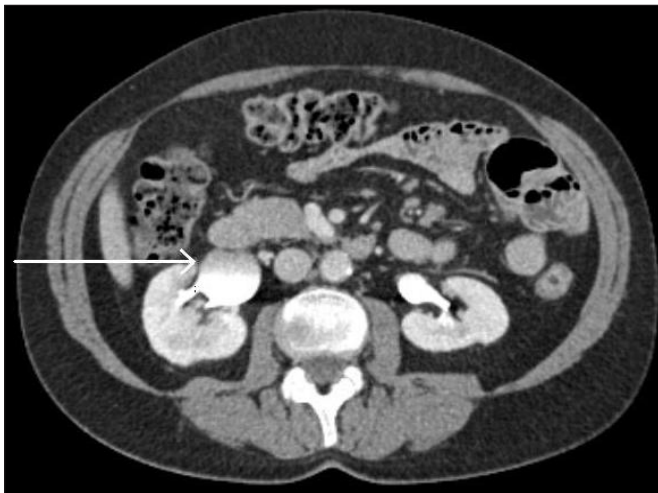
CT intravenous urogram, axial view: dilated right renal pelvis with retained contrast secondary to a PUJO.
